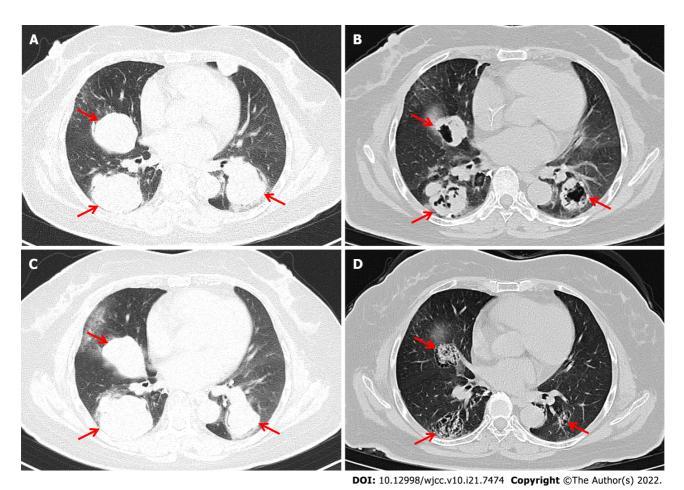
Computed tomography images scans showing changes in lung tumors after combined programmed cell death receptor-1 inhibitor therapy. Chest computed tomography images showing multiple metastases in bilateral lungs. The three metastases with the largest diameters were selected as target lesions (red arrow). A: The sizes of target lesions before PD-1 inhibitor combination treatment were 47.4 mm, 50.1 mm, and 48.4 mm (6/26/2019); B: The target lesions had regressed in size to 28.9 mm, 37.2 mm, and 32.0 mm after chemotherapy combined with immunotherapy (11/28/2019); C: The target lesions were 57.6 mm, 56.9 mm, and 51.2 mm after 4.4 mo discontinuing treatment (4/16/2020); D: Target lesions had regressed in size to 26.8 mm, 35.8 mm, and 24.3 mm after immunotherapy combined with anti-angiogenesis therapy and massive necrosis was clearly observed (12/23/2020).
